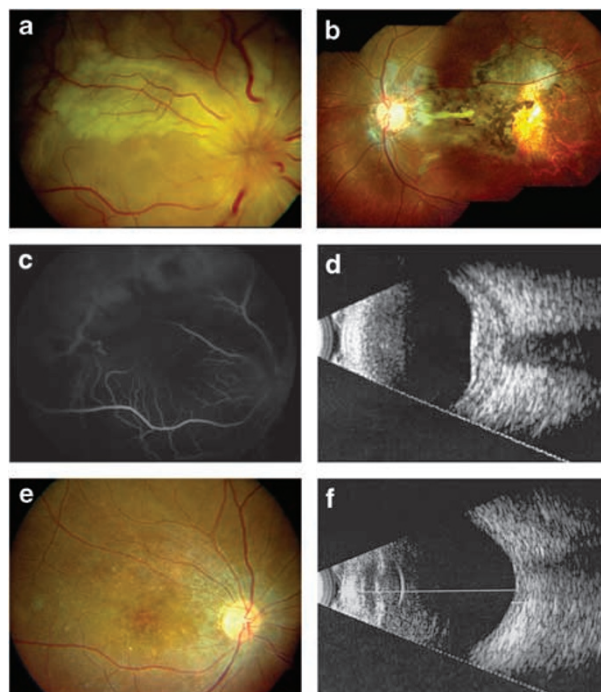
Clinical, angiographic, and ultrasonographic presentation, and post-treatment resolution of posterior scleritis with retinal artery occlusion and exudative detachment (a) Fundus view of the right eye, showing optic disc oedema, venous dilatation, serous retinal detachment, and segmental pallor along the superotemporal arcade, rendered less prominent by the turbidity of the subretinal fluid. (b) Left fundus showed the evidence of resolved inflammation with severe chorioretinal scarring, retinal pigment epithelial atrophy, and pigment migration. (c) Midphase fluorescein angiogram shows delayed transit of dye from the superotemporal branch retinal artery, with empty corresponding capillaries and vein. The faint choroidal hyperfluorescence is probably indicative of associated inflammatory activity. (d) B-scan ultrasound through the right optic nerve shows gross hyper-reflective thickening of the retina-choroid-sclera complex (5.06 mm), fluid in the sub-Tenon's space (T-sign), and squaring of the optic nerve shadow. (e) 4 months later, the fundus shows complete resolution of the inflammatory and vascular sequelae, with residual granular pigmentary stippling of the posterior pole. (f) B-scan confirms the resolution of scleral thickness (1.39 mm) and sub-Tenon's fluid, with normalised optic nerve shadow.
